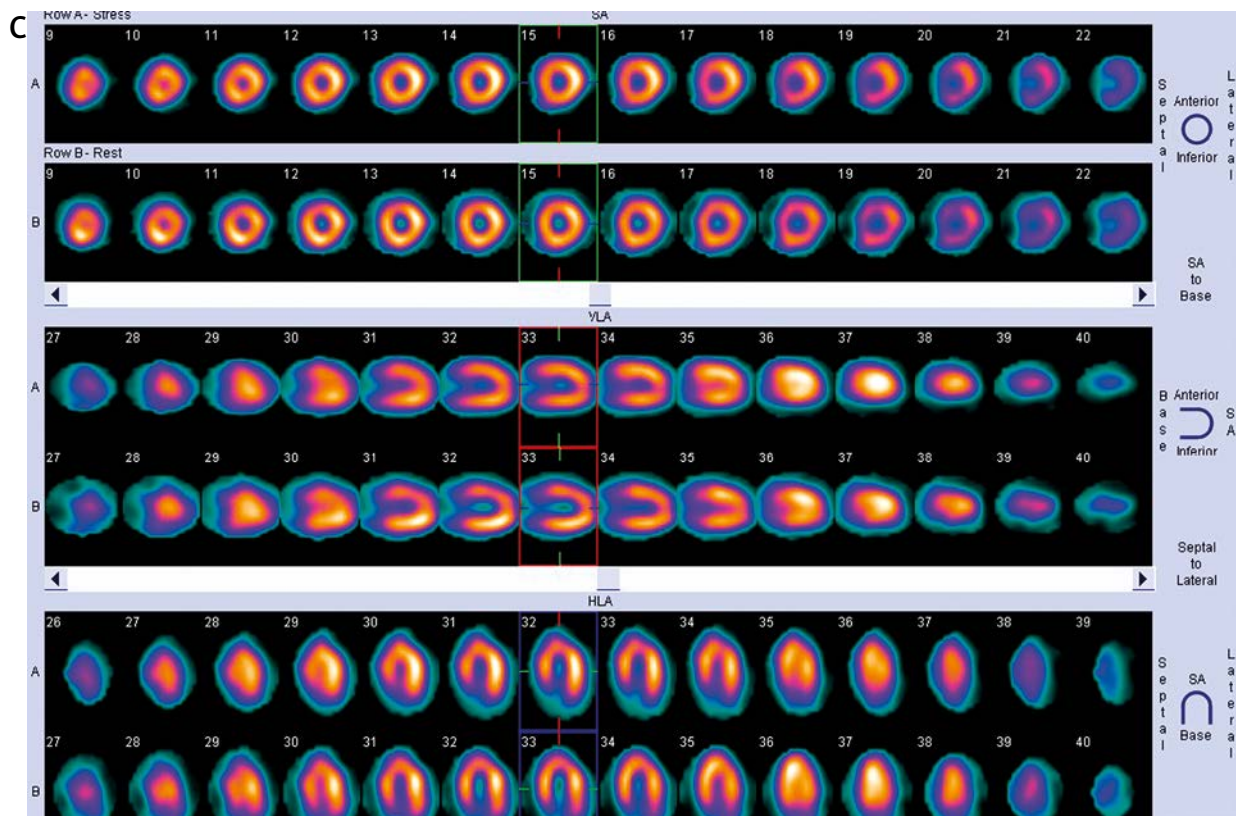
C – Myocardial perfusion scintigraphy showed no ischemia
